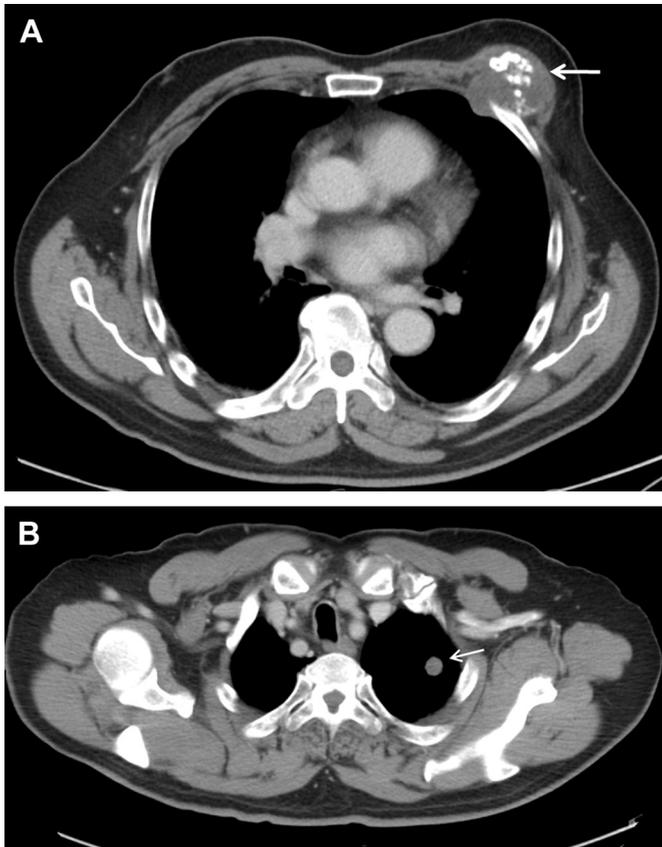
Chest computed tomography (CT) scan demonstrating (A) a heterogeneous soft tissue mass with calcification (arrow) involving the anterior segment of the left fourth rib and (B) a nodular lesion about 2 cm in diameter (arrow) in the left upper lobe.
